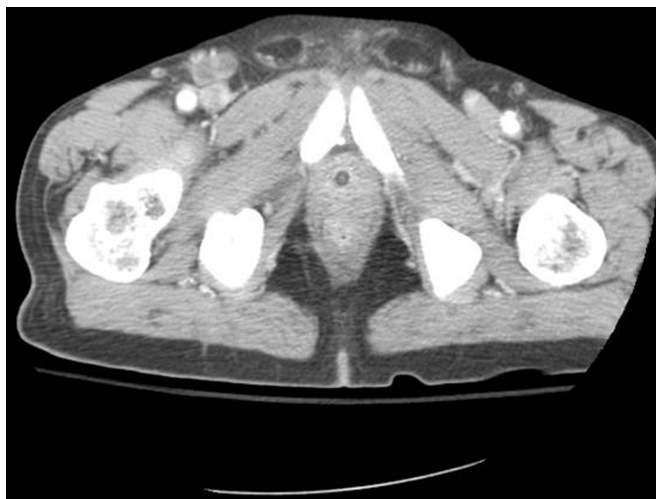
Computed tomographic scan demonstrates right femoral hernia with incarcerated small bowel.
